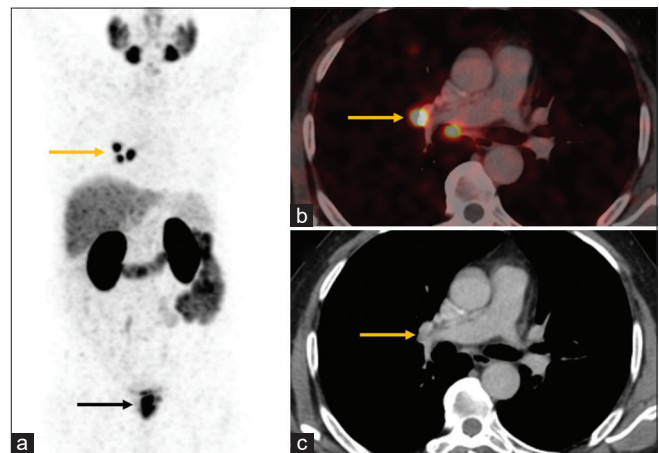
This is a case of a 61-year-old patient with adenocarcinoma prostate with Gleason score 4+5=9 and serum PSA of 51ng/ml. MIP image (a) of 68Ga PSMA PET/CECT scan done for baseline staging shows increased tracer uptake in the prostate (black arrow) and mediastinal nodes (SUVmax 14.23) (yellow arrow). No pelvic or retroperitoneal nodes were identified. Axial fused and CT images (b & c) shows elongated tiny sub cm sized mediastinal nodes. On the basis of location and morphology of these nodes and in the absence of any regional nodes, the mediastinal nodes were reckoned benign/infective. Patient received radiation therapy to the primary site following which he had falling PSA trend and is doing clinically well
